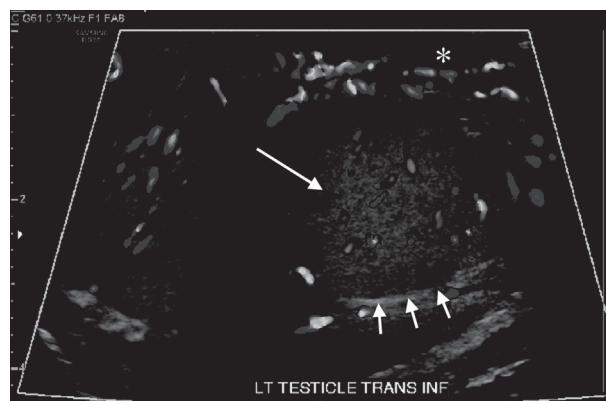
Testicular ultrasound demonstrating the left testis (white arrow) with normal echogenicity, shape, and contour. The tunica albuginea (white arrows with short tails) seen as a peripheral echogenic line. Doppler examination showing vascular flow of both testes.
